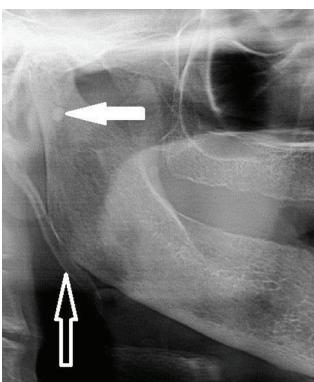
Panoramic image (cropped). The radiopaque outlines of an ossified stylohyoid ligament (open arrow), passing the angle of the mandible, are present in this radiograph of a 77-year-old female. A calcification within Stensen's duct of the parotid gland can also be seen projecting onto the upper part of the ramus (solid arrow).
